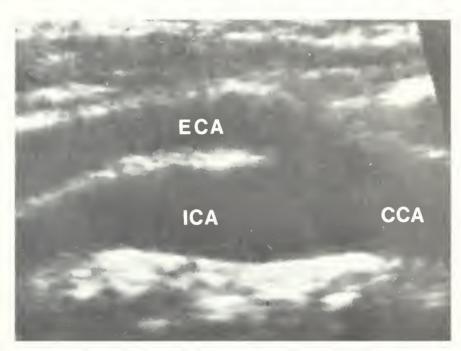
Longitudinal sonogram showing a normal common carotid artery (CCA), internal carotid artery (ICA), and external carotid artery (ECA).
